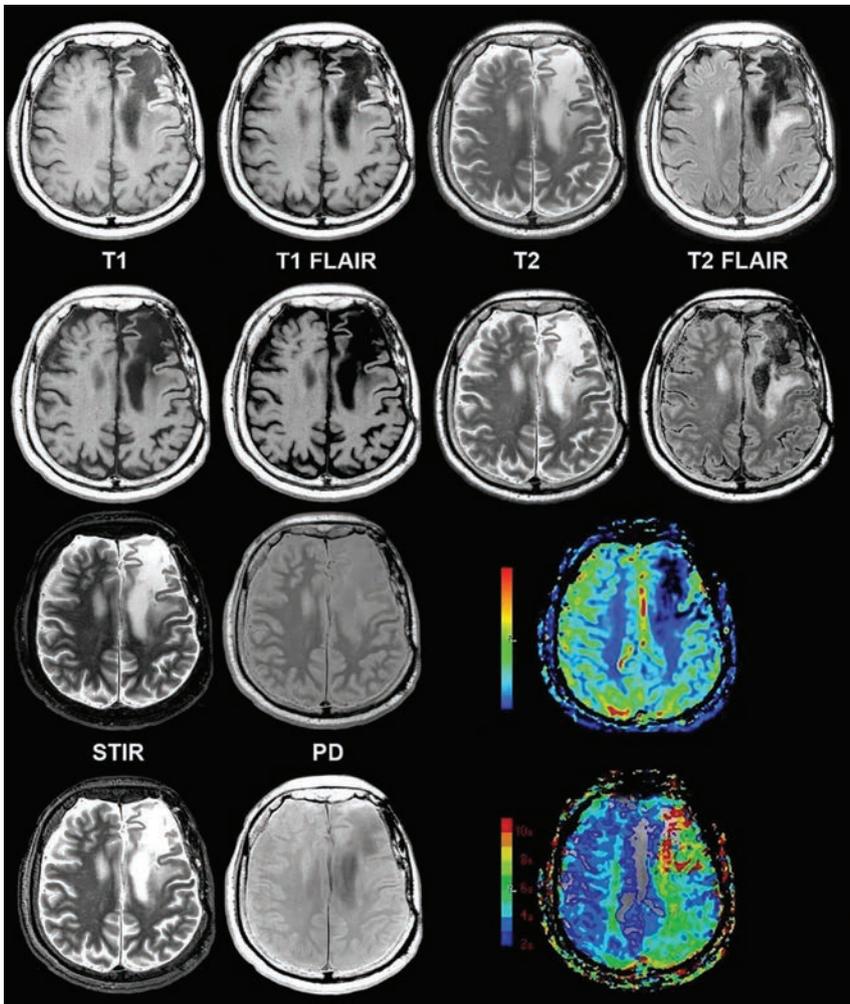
Chronic infarction in synthetic and conventional 3T MR imaging shown alongside color functional perfusion maps in a 62-year-old man. Conventional (rows 1 and 3) and synthetic (rows 2 and 4) views show similar legibility and quality. T1 FLAIR and T2 FLAIR views have some granulated white noise in the margins. Color quantitative perfusion maps (lower right) demonstrate decreased flow and prolonged transit time in this region of chronic infarction.
